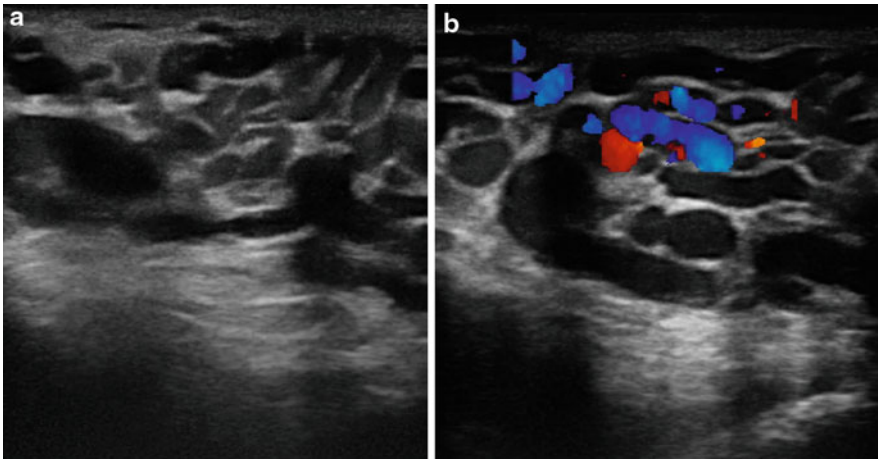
Ultrasound exploration of left varicocele. No standard or clearly defined criteria for varicocele diagnosis by ultrasound exists to date. However, most clinicians agree
